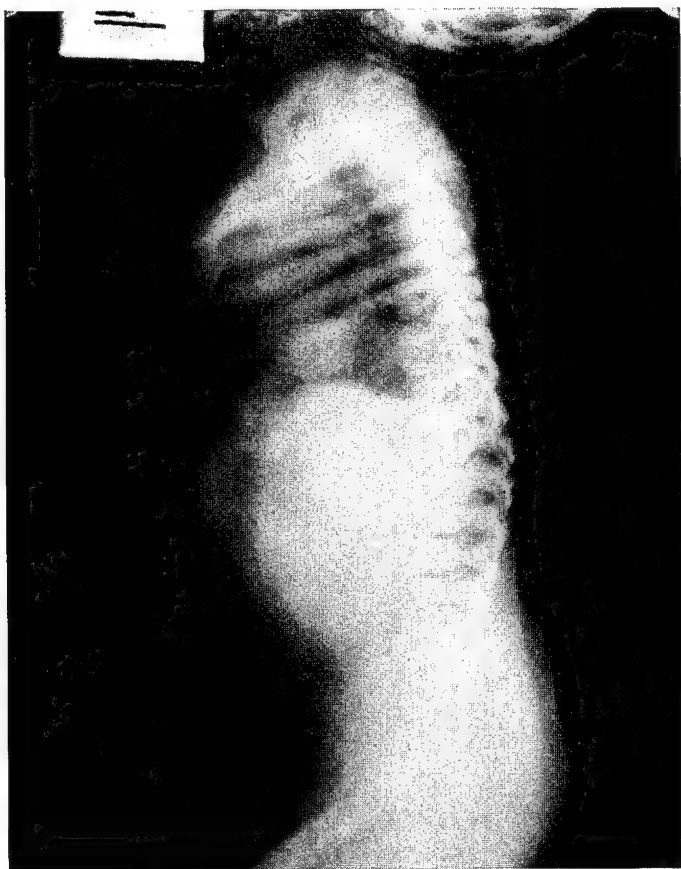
Roentgenogram of thorax and hip.
